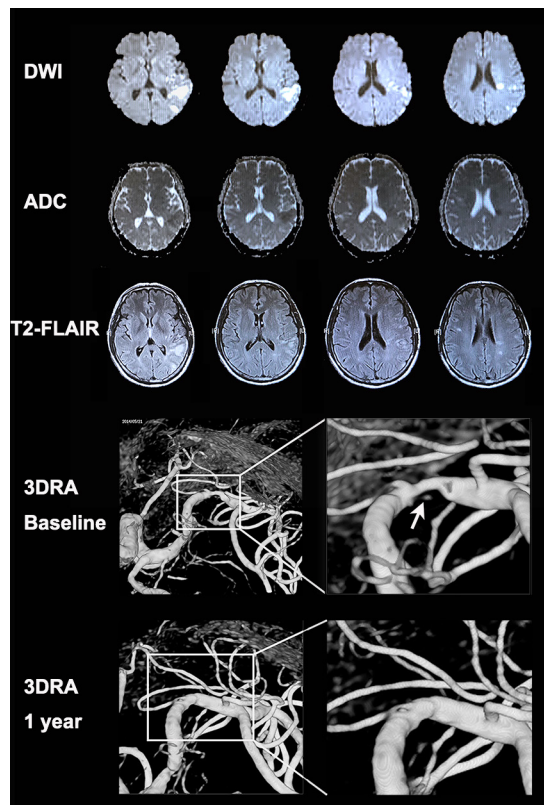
MRI and 3DRA images of a patient with an ulcerative MCA-M1 plaque and coexisting acute and chronic infarcts in cortical and subcortical regions. A patient with a history of hypertension presented with sudden onset of expressive dysphasia. The MRI exam conducted 1 day after symptom onset showed a cluster of early infarcts (high signal in DWI and low signal in apparent diffusion coefficient maps) at left posterior corona radiata (internal borderzone) and left temporal–parietal cortical and subcortical regions (including the posterior borderzone). There were also older small infarcts (high signal in T2 fluid-attenuated inversion recovery imaging and iso-intensity signal in apparent diffusion coefficient maps) in the same regions. The 3DRA exam conducted 4 weeks after the index stroke showed 80% stenosis of the left MCA-M1 with an ulcer in the plaque surface, that is, contrast appearing beneath the surface outline of the plaque (arrow). The patient received aspirin and clopidogrel treatment for 4 weeks since admission followed by lifelong aspirin treatment, in conjunction with stringent vascular risk factor control. The patient had no recurrent ischaemic stroke within 1 year after the index stroke. A repeated 3DRA exam at 1 year showed healing of the previously ulcerated MCA-M1 plaque. 3DRA, 3-dimensional rotational angiography; DWI, diffusion-weighted imaging; MCA-M1, M1 middle cerebral artery.
